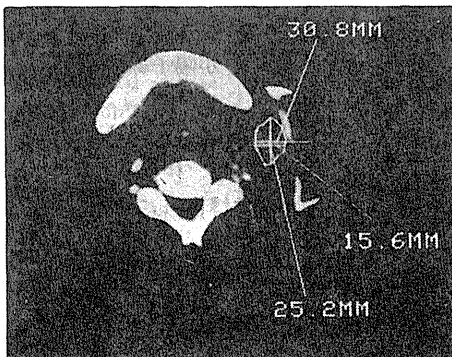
CT view of malignant melanoma metastatic to neck.
